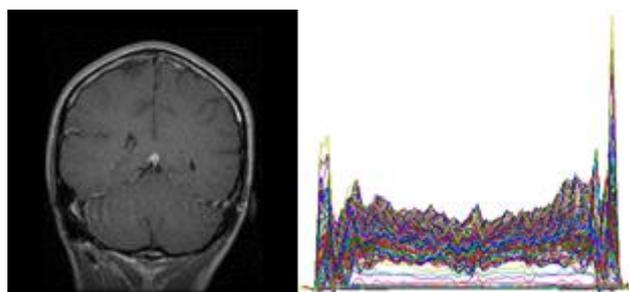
Brain imaging modality MRI-T1 (left) and the representation of covariance histogram of all pixels in image M (right).
